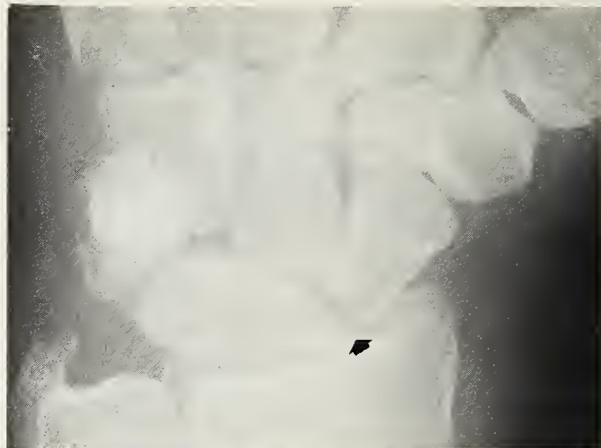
Radiograph showing a fracture through the proximal third of the scaphoid.
